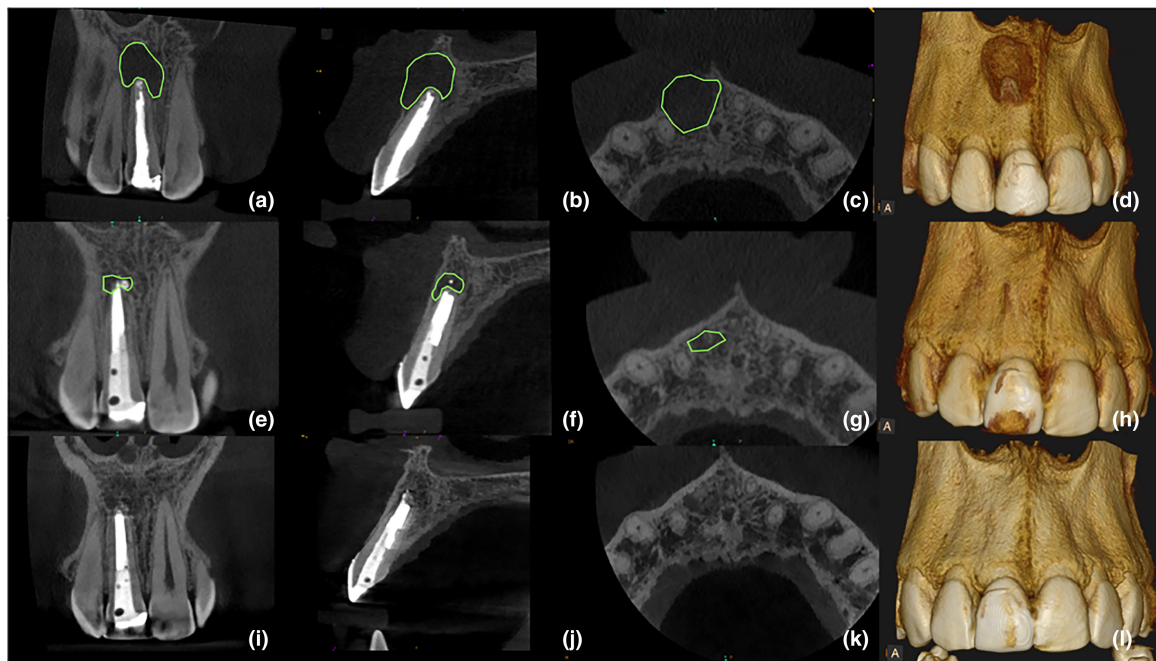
Multiplanar reconstructed CBCT images of a healed case at 24 months follow-up. Preoperative (a-d), 12 months follow-up (e-h) and 24 months follow-up (i-l).
